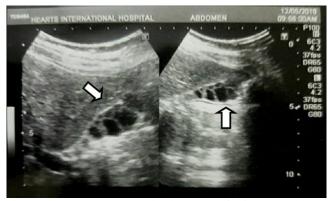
Ultrasonographic image of liver and gall bladder, showing multiple septa dividing the gall bladder lumen into different compartments (MSG).
